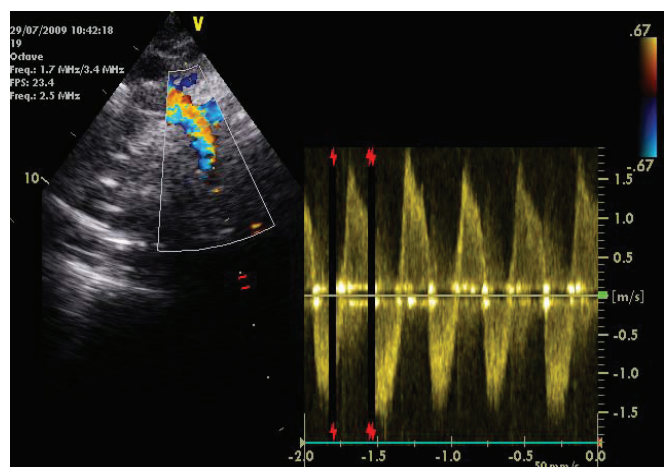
Pre-operative two-dimensional echocardiogram in the parasternal (long/short-axis) view showing diastolic flow reversal in the descending aorta, suggestive of severe aortic regurgitation.
